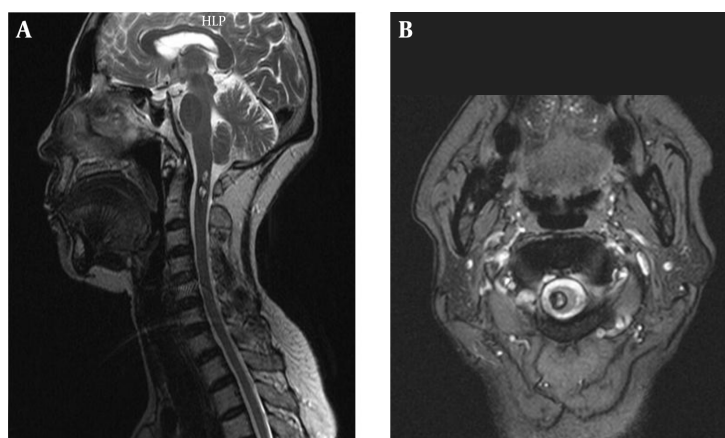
Cervical MRI showing a round intramedullary lesion located at the C2 level, exhibiting a core of increased signal intensity, surrounded by a low signal intensity rim on the sagittal T2-weighted images (A) and the axial T2-weighted images (B). These demonstrated that the lesion was located in the right dorsal horn.
